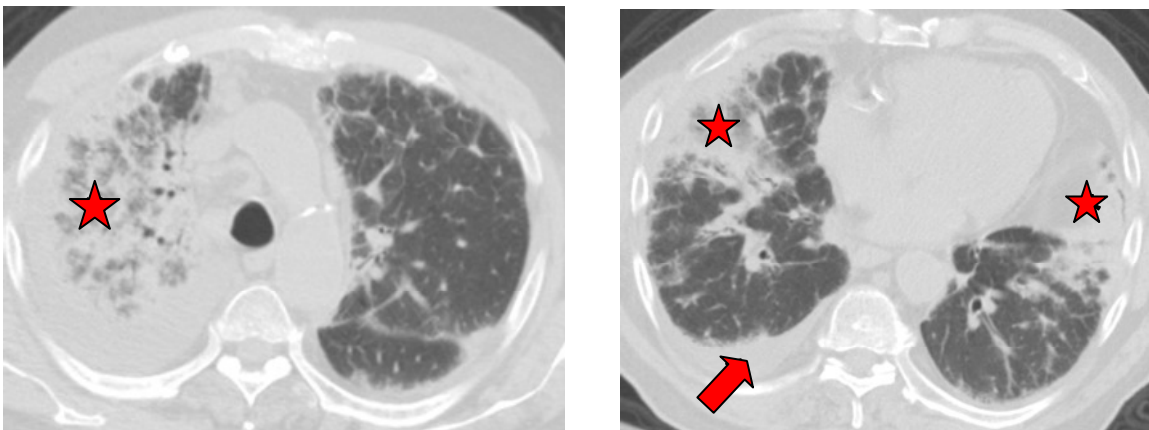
A high resolution CT scan of the lung showed mild right pleural effusion (arrow) and right upper lobe, right lower lobe, and lingular infiltrate (stars).
